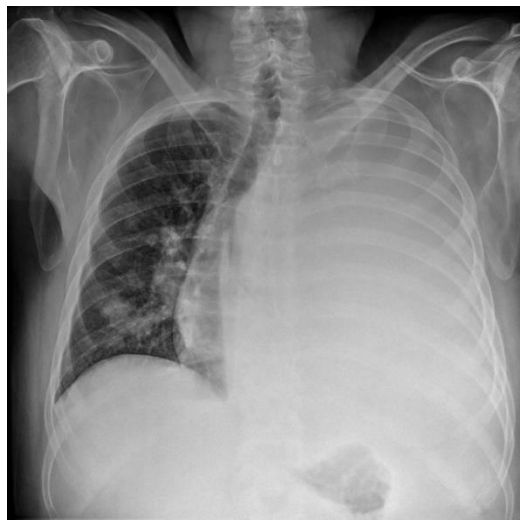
Hemithorax Opacification ('whiteout'). A ‘whiteout’ on a chest x-ray can be a pleural effusion, atelectasis, mucus plugging, or 13 other differentials. This makes differential diagnosis difficult for physiotherapists. (Source: Dawes et al. 2022)
